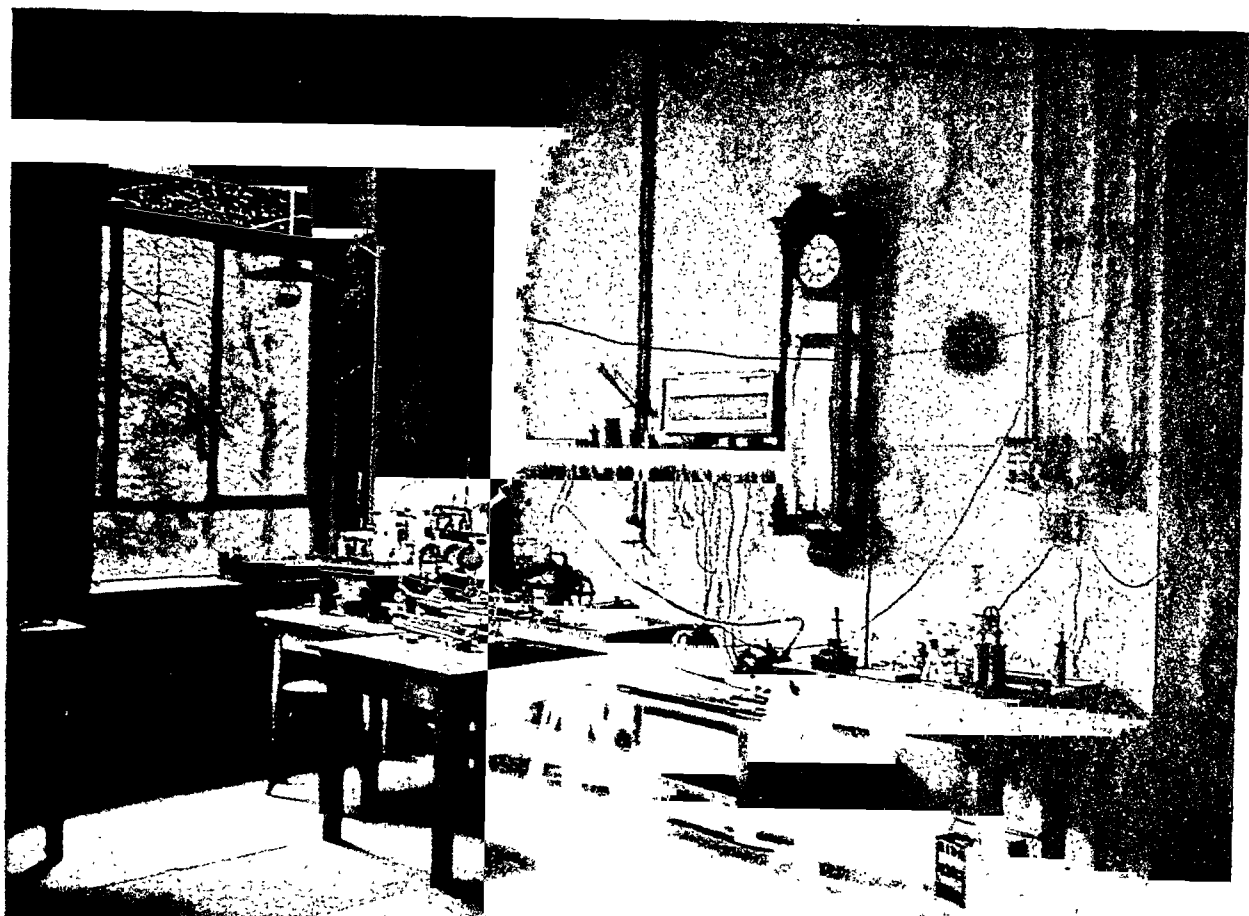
Laboratory room in which Röntgen discovered the x-ray. By 1923 when this photograph was made, electrical conduits, outlets and motors had been added but the clock, stools and benches were used by Röntgen. At the extreme right of this photograph is the edge of the door that is pictured in Figure 4.
